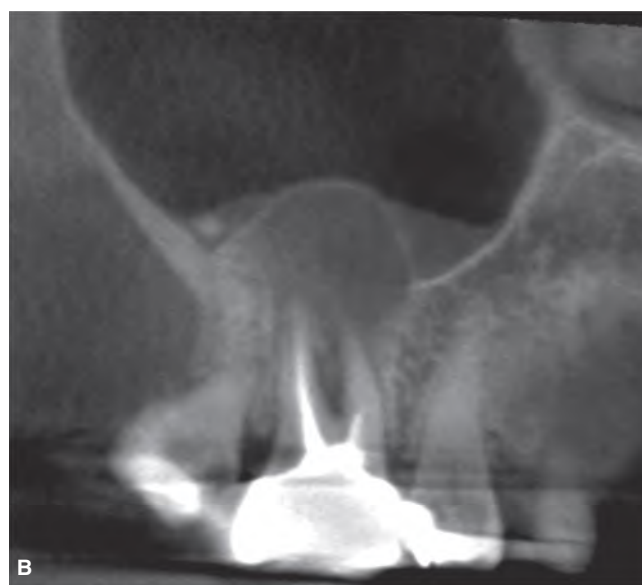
Periapical osteoperiostitis (“halo” lesion). A. Periapical radiograph of a failing root canal treatment of the maxillary right first molar. Apical periodontitis has displaced the periosteum into the sinus and new cortical bone has formed on the periphery of the disease process creating the appearance of a “halo” on the radiograph (arrows). B. Sagittal CBCT image of the periapical osteoperiostitis lesion. Sinus mucosal edema, or fluid, is also evident on the sinus floor adjacent to the lesion.
